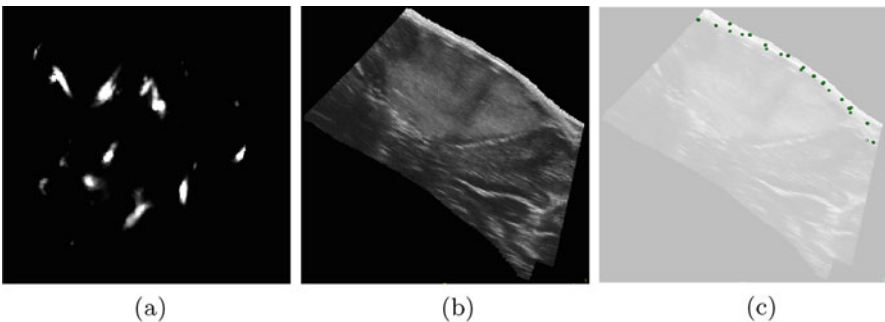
Extraction of the probe footprint in US B mode images. (a) Doppler Image. (b) B mode image. (c) Point cloud generation
